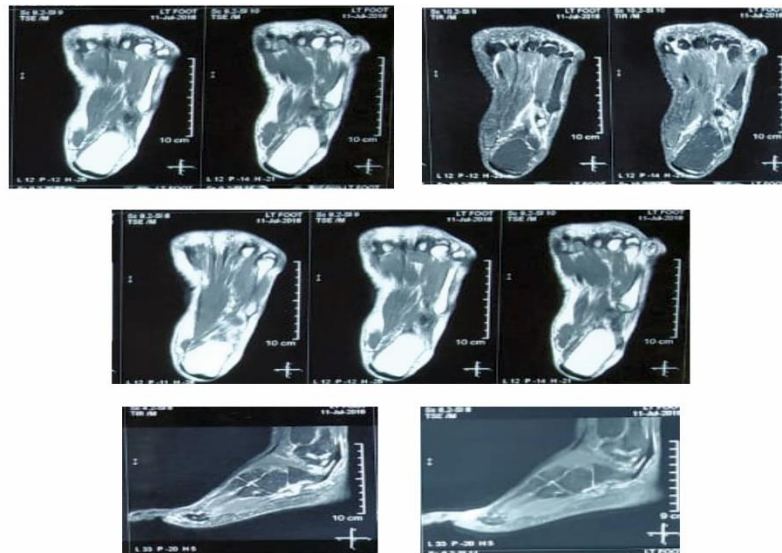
52-year-old male left midfoot MRI. show the osperoneum within the peroneal tendon. It showed two well corticated lesion in the peroneus longus tendon at the level of calcaneum cuboid joint. Also, there was edema and intense enhancement in the adjacent soft tissues The peroneus longus tendon was thickened and heterogeneous, consistent with tendinopathy
